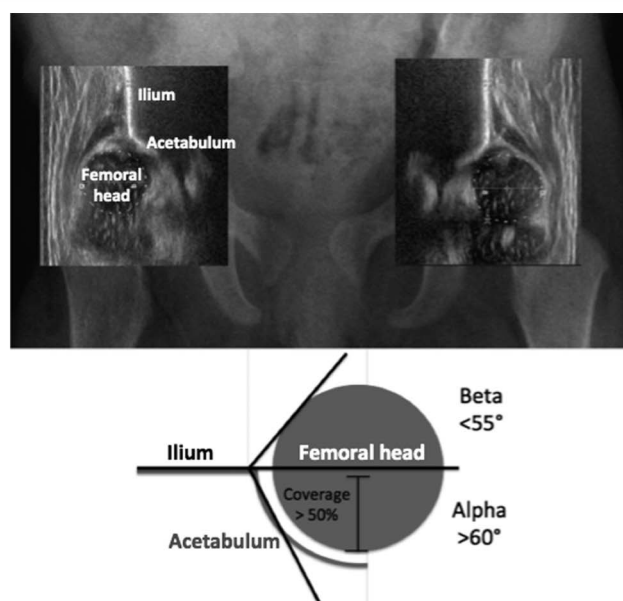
Figure demonstrating the ultrasound in relation to an AP radiograph, using measurements of coverage, alpha and beta angles on a coronal image.
